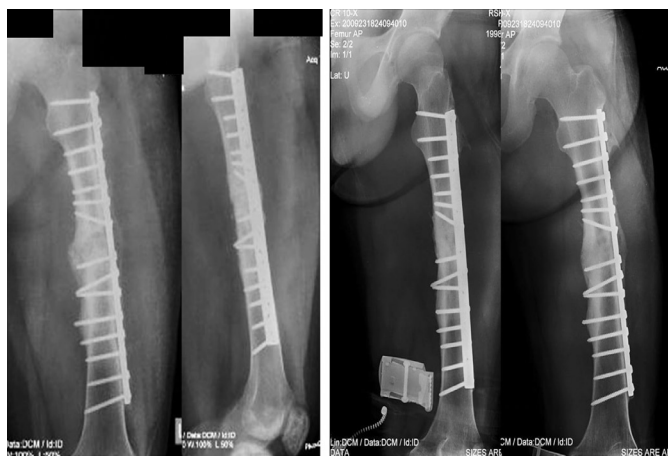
Seven months follow-up after the 4th surgery (left) showed abundant bridging callus. One year follow-up X-Rays (Right) after the 4th surgery showed a radiological union.
